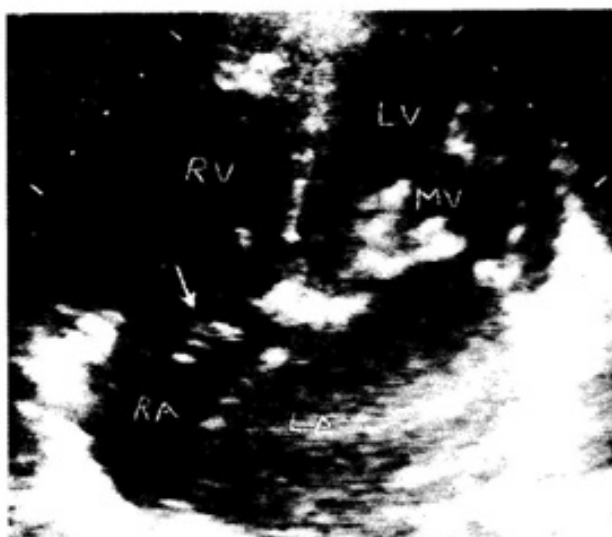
Apical four chamber view of Chiari network with rheumatic mitral valve.
